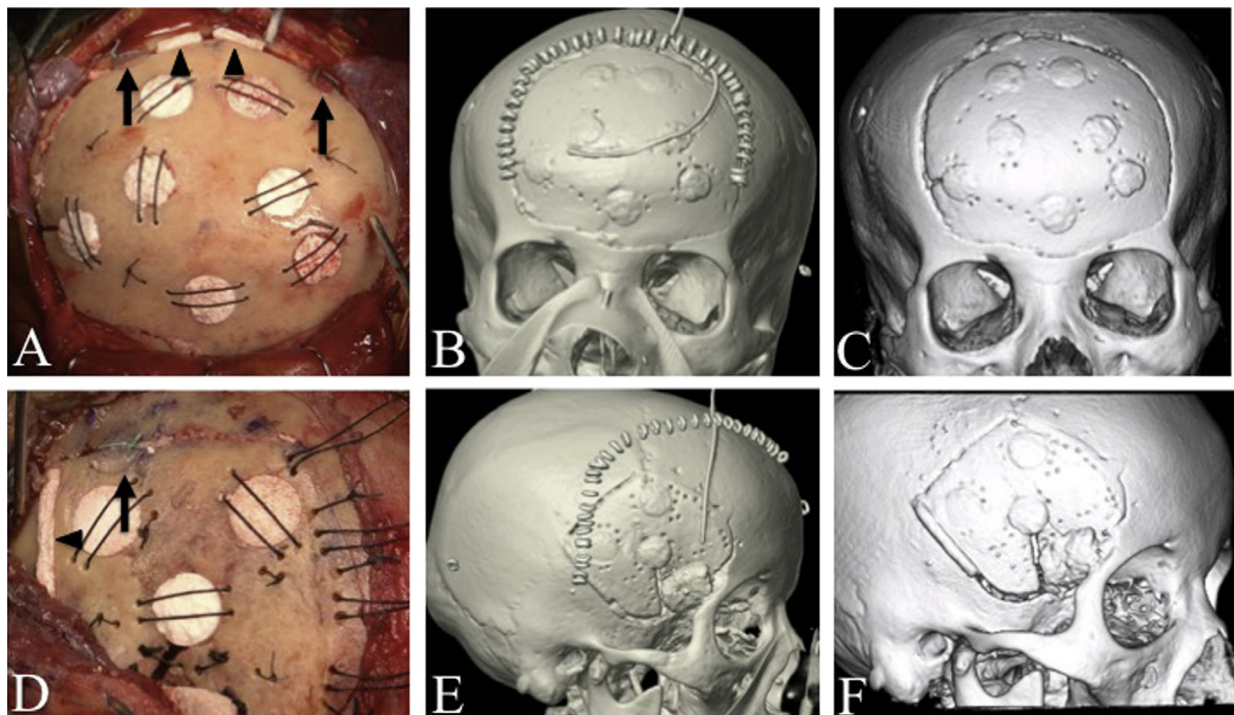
PBFF in bifrontal and frontotemporal craniotomy. Black arrows indicate AC and black arrow heads indicate HW in bifrontal craniotomy (A). 3D CT scan of bone image showed that a bone flap is in a good anatomic position (B), and bone flap depression and resorption were not observed at 6-month (C). Black arrows indicate AC and black arrow heads indicate HW in right frontotemporal craniotomy (D). 3D CT scan of bone image showed that a bone flap is in a good anatomic position (E), and bone flap depression and resorption were not observed at 6-month (F). Abbreviation: AC, absorbable craniofix; HW, hydroxyapatite wedge; PBFF, pressure-bonding bone flap fixation.
